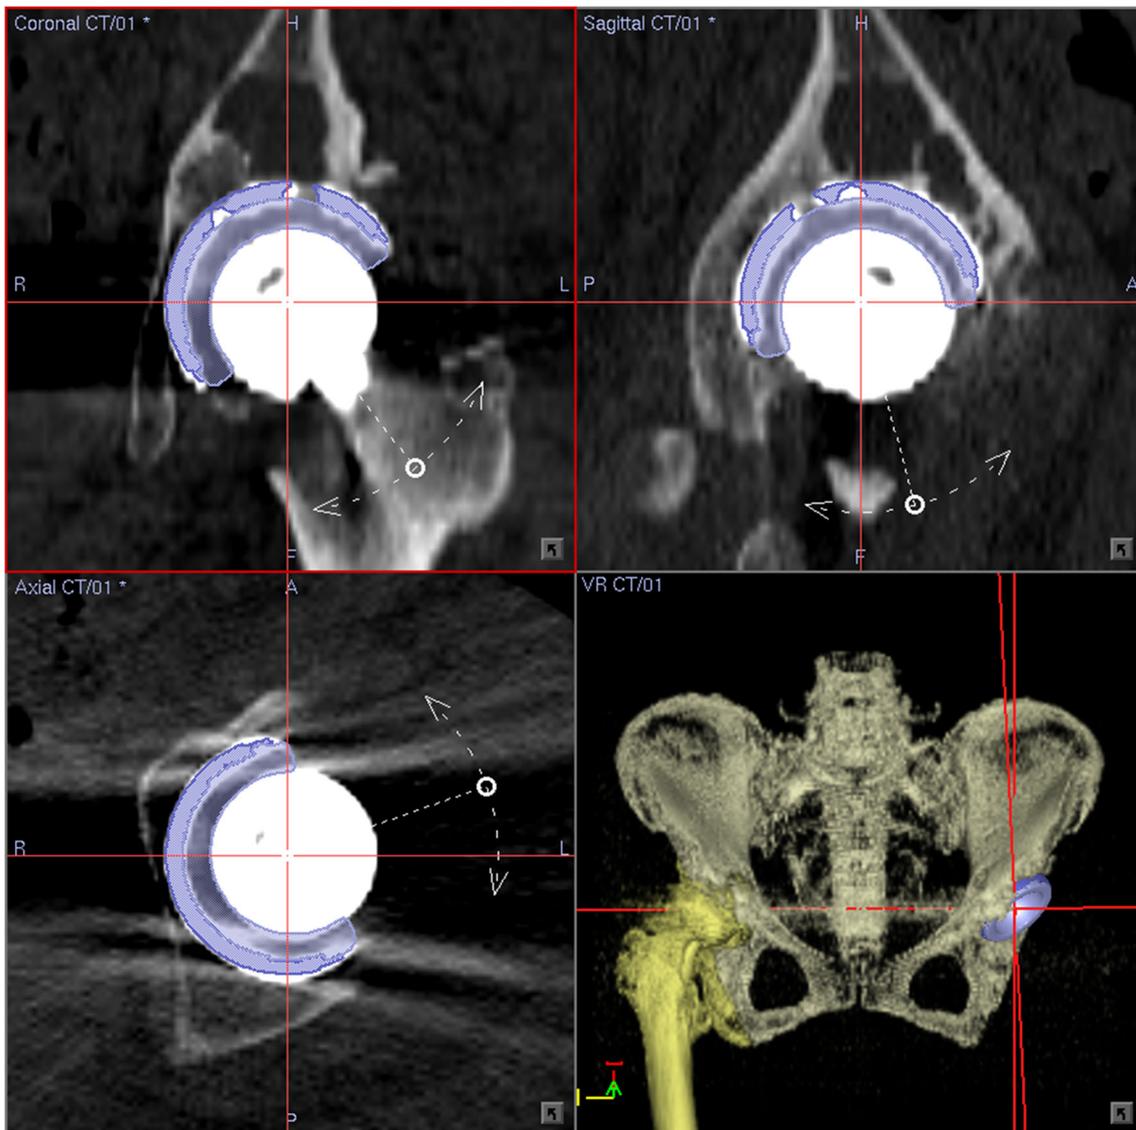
Cup alignment was measured using computer software. The CAD data of the acetabular component was superimposed on the 3D-CT image
